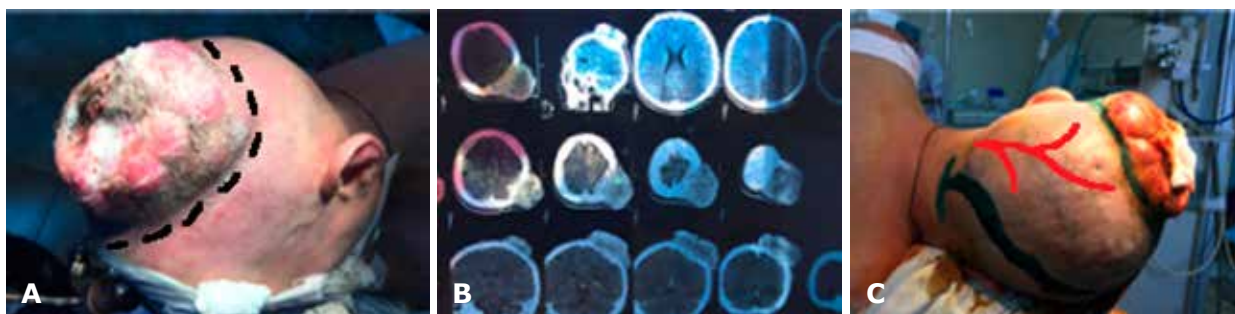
Patient K.: A - appearance of the patient before surgery; B - MRI data before surgery; C - marking the operation plan on the operating table
